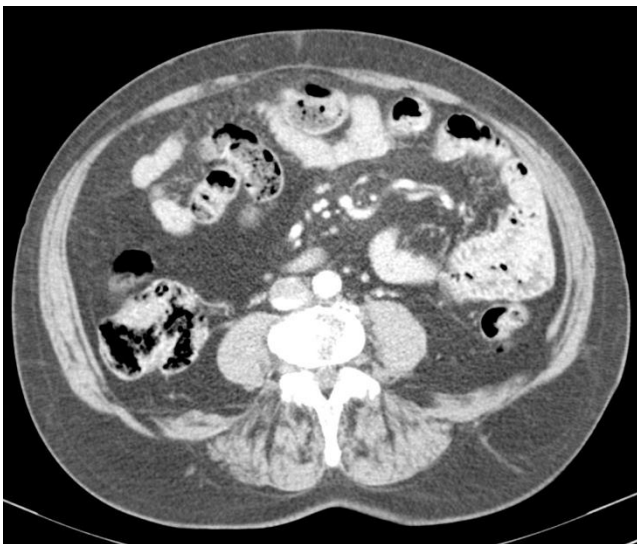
Abdominal CT scan with contrast.
